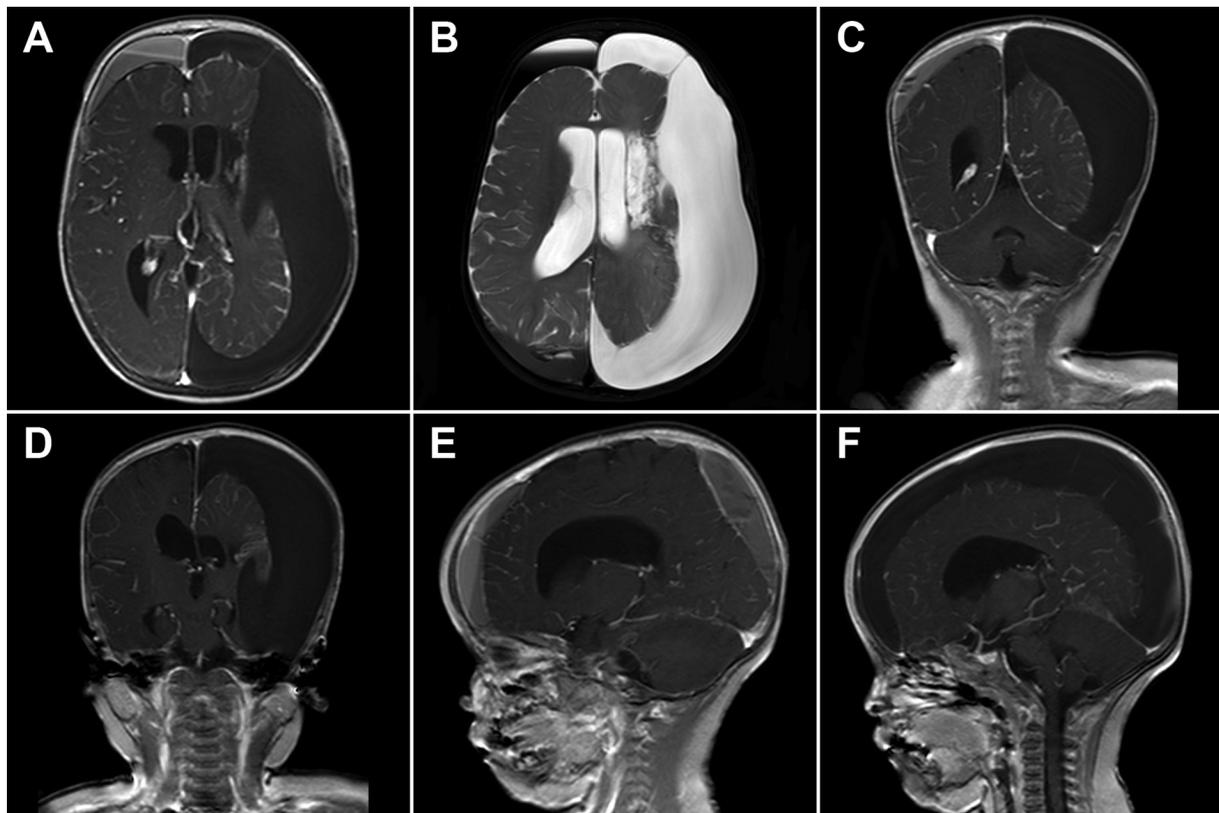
A–F are Post-operative MRI showing increased in volume of hydrooma at left frontal and temporal regions and formation of subdural hematoma at right frontal lobe three months after operation.
